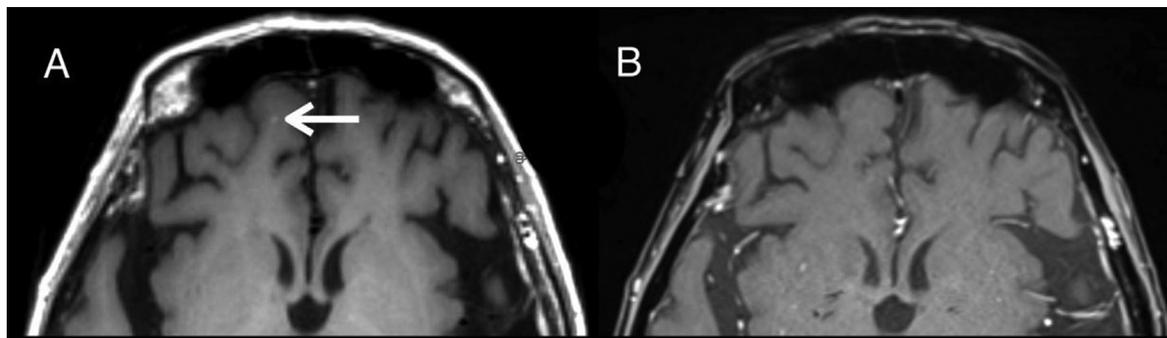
A 53-year-old breast cancer patient with a tiny metastasis in the right frontal lobe (white arrow) that was not visible on contrast-enhanced 3D T1-weighted VIBE in head-to-head analysis. Axial contrast-enhanced 3D T1-weighted SPACE (A) shows a tiny enhancing lesion while contrast-enhanced 3D T1-weighted VIBE (B) shows no visible lesion.
